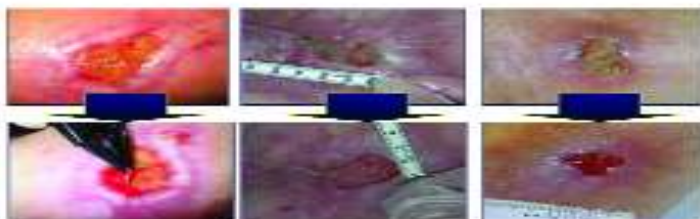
Wound debridement. Ultrasound activates inflammatory cells, which results in wound debridement.
